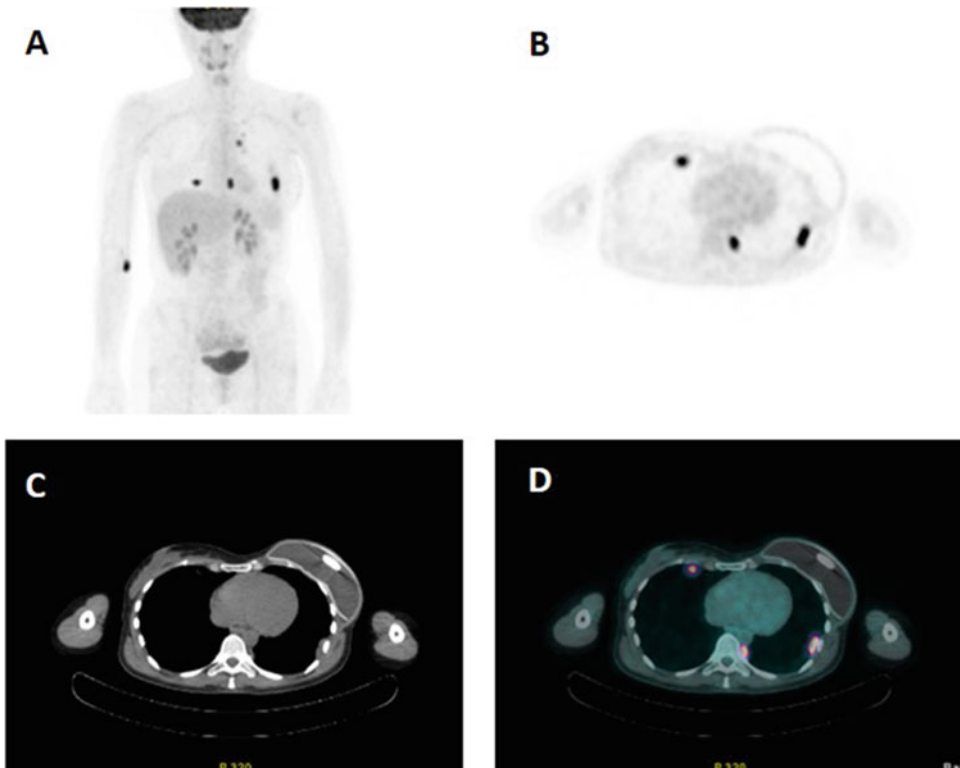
[^{18}F]FDG PET/CT of nodular pleural thickenings (a, MIP; b, transaxial PET; c, transaxial CT; d, transaxial fused PET/CT)
